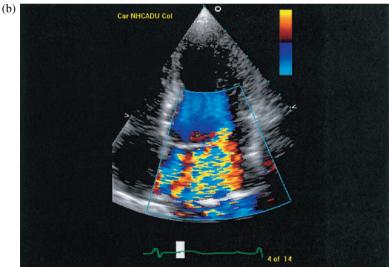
a) Zoom parasternal long axis view of the mitral valve showing bileaflet prolapse. b) Apical 4-chamber view showing severe mitral regurgitation.
